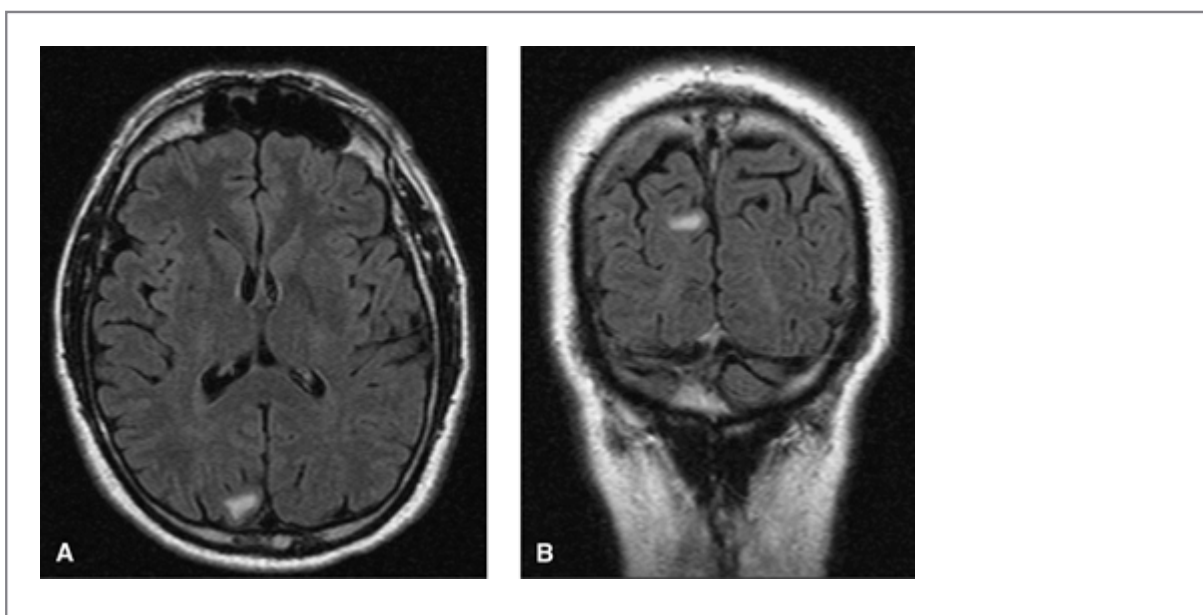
Poststroke occipital epilepsy. A, B: This is a magnetic resonance image of the brain in a 53-year-old male smoker and drinker with a right occipital infarct, mild left homonymous visual scotoma, and complex partial seizures with an aura of autonomic symptoms of epigastric sensation, facial flushing, and dizziness associated with “graying out” of his vision prior to loss of consciousness. Routine electroencephalography was normal and seizures are controlled by carbamazepine.
